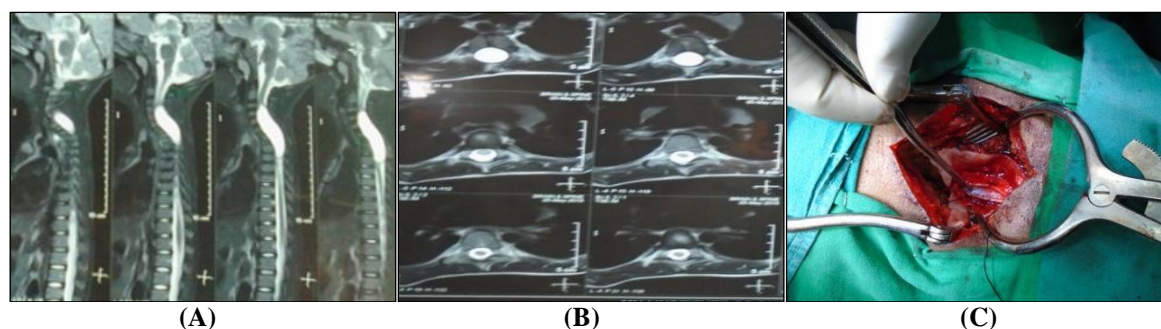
Case 9. A 7-year-old male child presented with a 6 months history of gait ataxia while playing and progressive weakness of all 4 limbs. Sagittal (A) and Axial (B) T2-weighted MR images showing dorsal compression of spinal cord. Surgical exploration revealed a spinal arachnoid cyst at C4-D4 level (cervico dorsal), which was completely resected (C)
